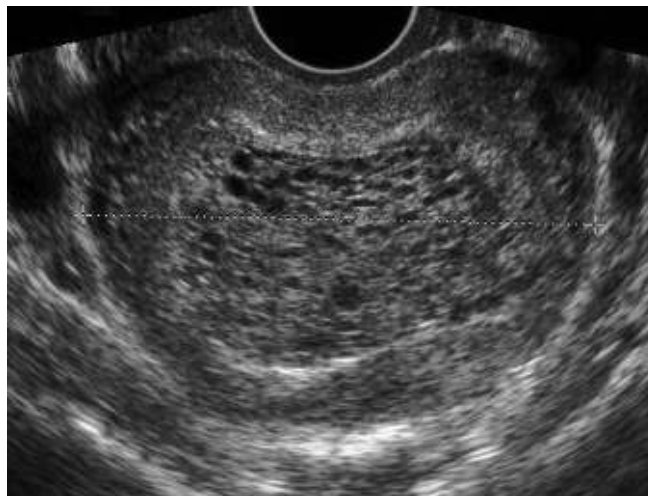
Gestational trophoblastic disease. The classic “snowstorm” appearance is seen on transverse ultrasound of a patient with gestational trophoblastic disease. The patient has a complete hydatidiform mole. (Reproduced with permission from Hoffman BL et al. *Williams Gynecology*, 2nd ed. New York: McGraw-Hill, 2012, Fig. 37-5.)
